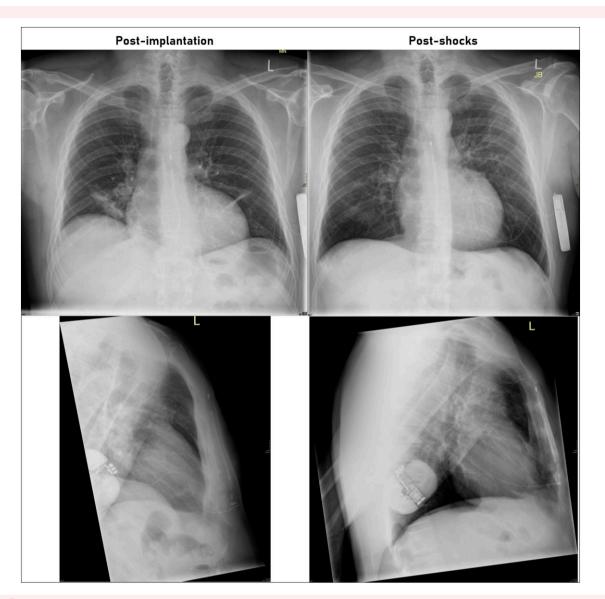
Radiographs of the device. (Left) Immediate post-implantation films. Neither film shows the full extent of the device. The generator header can be seen facing anteriorly and level with the posterior heart border on the lateral film. Bilateral lower zone atelectasis is seen. (Right) Films following inappropriate shocks. The postero-anterior film (top right) shows preserved lead electrode position; the change in lead slack is not immediately obvious but the projection of the lead has changed from mid-generator to high on the generator. The lateral film confirms rotation and posterior displacement of the device, with a significant reduction in lead slack. The atelectasis seen on the first films has resolved.
